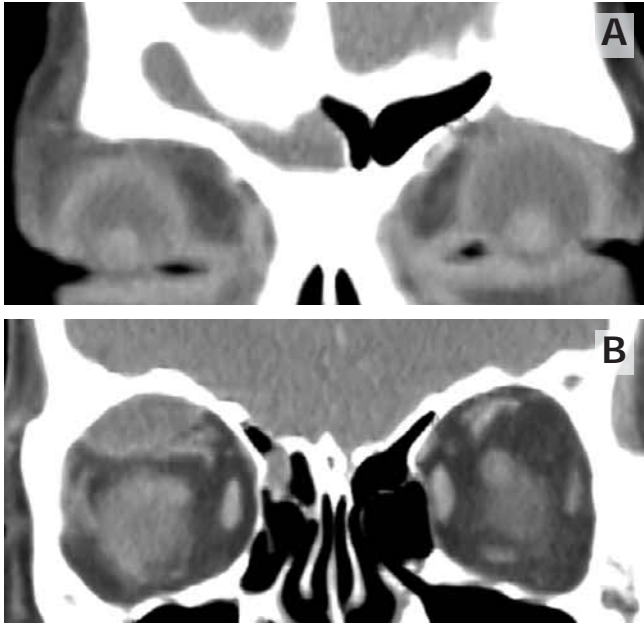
Case 1. (A) Contrast-enhanced computed tomography showing a clouded right frontal sinus and (B) a well-demarcated biconvex non-enhancing soft tissue density lesion in the right supraorbital area.
